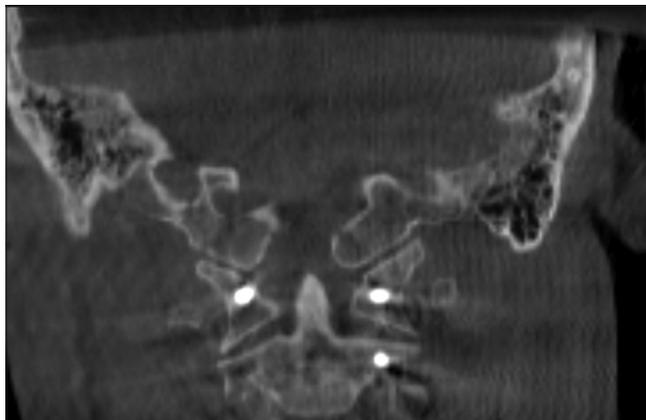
Postoperative computed tomography cervical spine (coronal view) shows reduction of both occipital condyle fractures.
